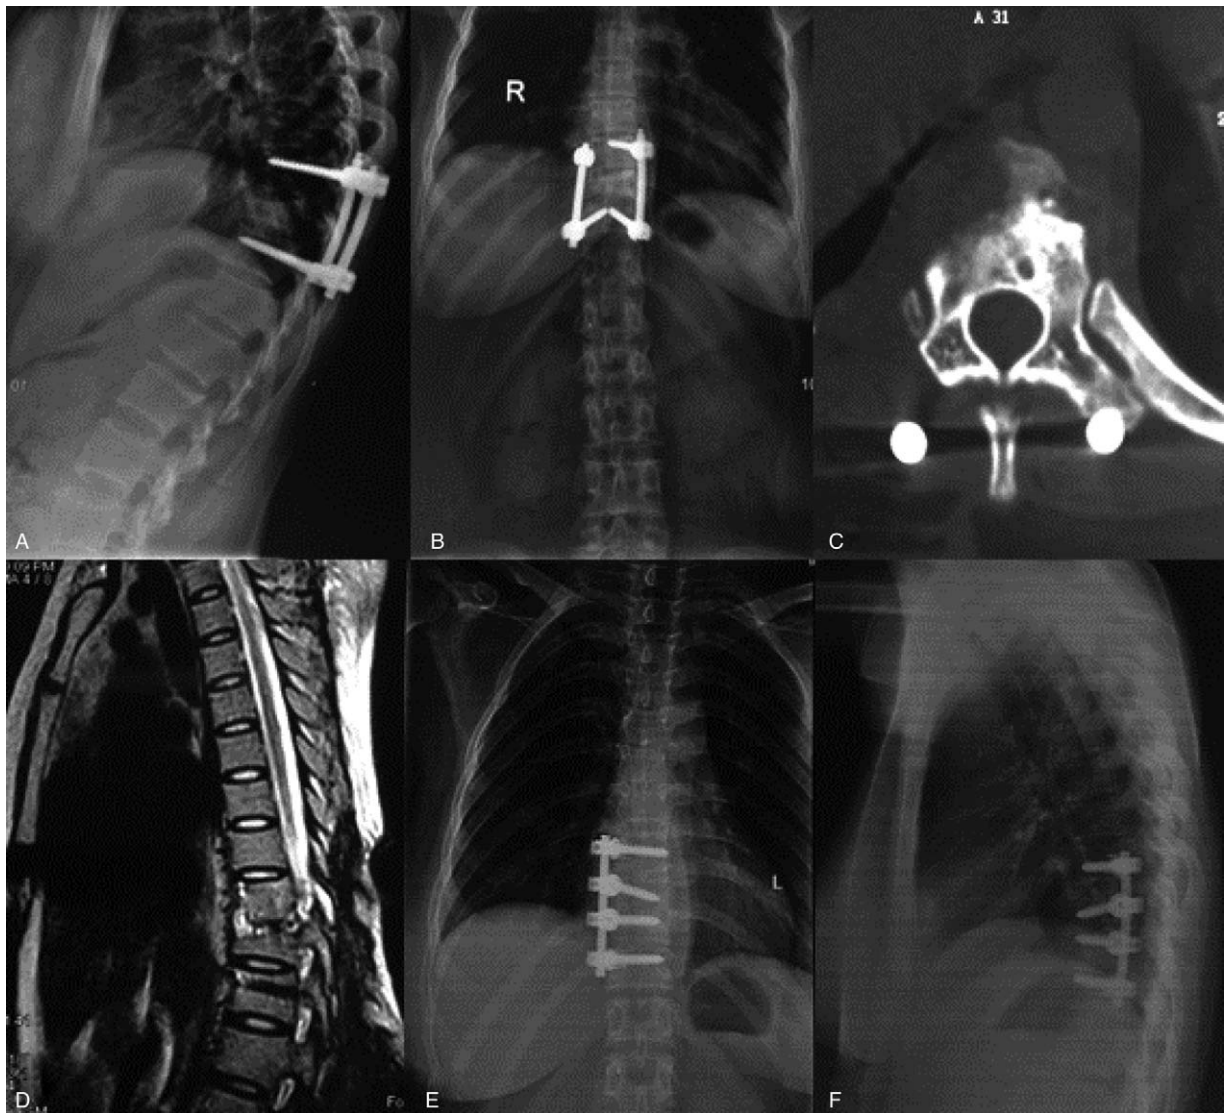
Case 1: A 56-year-old man was diagnosed as tuberculosis recurrence after anterior operation. (A, B) Radiograph showed tuberculosis recurrence after operation. (C, D) CT scan and MRI found the vertebral bone destruction and paravertebral abscess formation at the area of thoracic spine. Anterior debridement, instrumentation and allograft were performed on the patient. (E, F) X-ray at the final follow-up found the kyphotic angle was corrected and good bone fusion.
